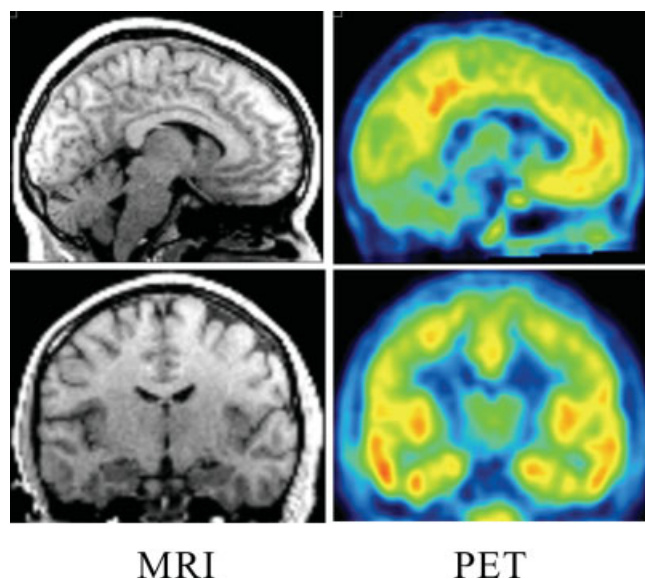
Activity of [^{11}C](R)-(-)-RWAY in human brain. Summed PET images are on the right, and the corresponding MR images are on the left. The sagittal and coronal brain sections are located in the upper and lower panel, respectively.
